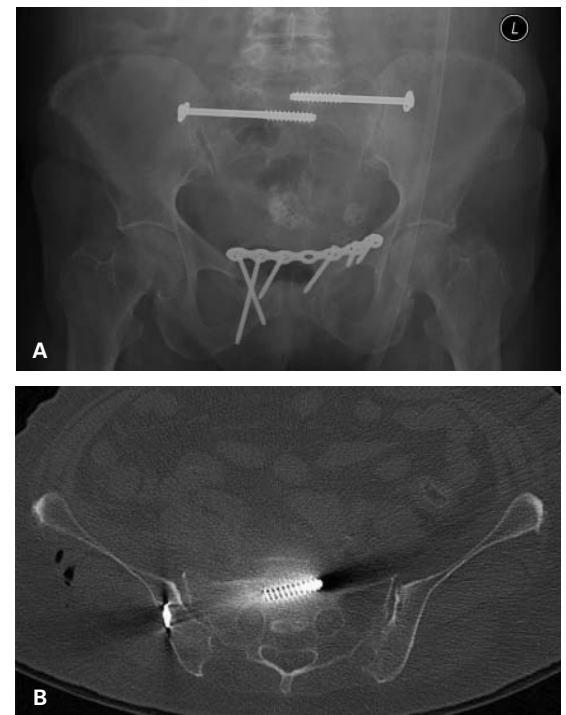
(A) AP pelvis demonstrating screw with intact iliac cortex on left and breach of iliac cortex by screw and washer on right. (B) Axial CT image depicting breach of the right iliac cortex by screw and washer.
